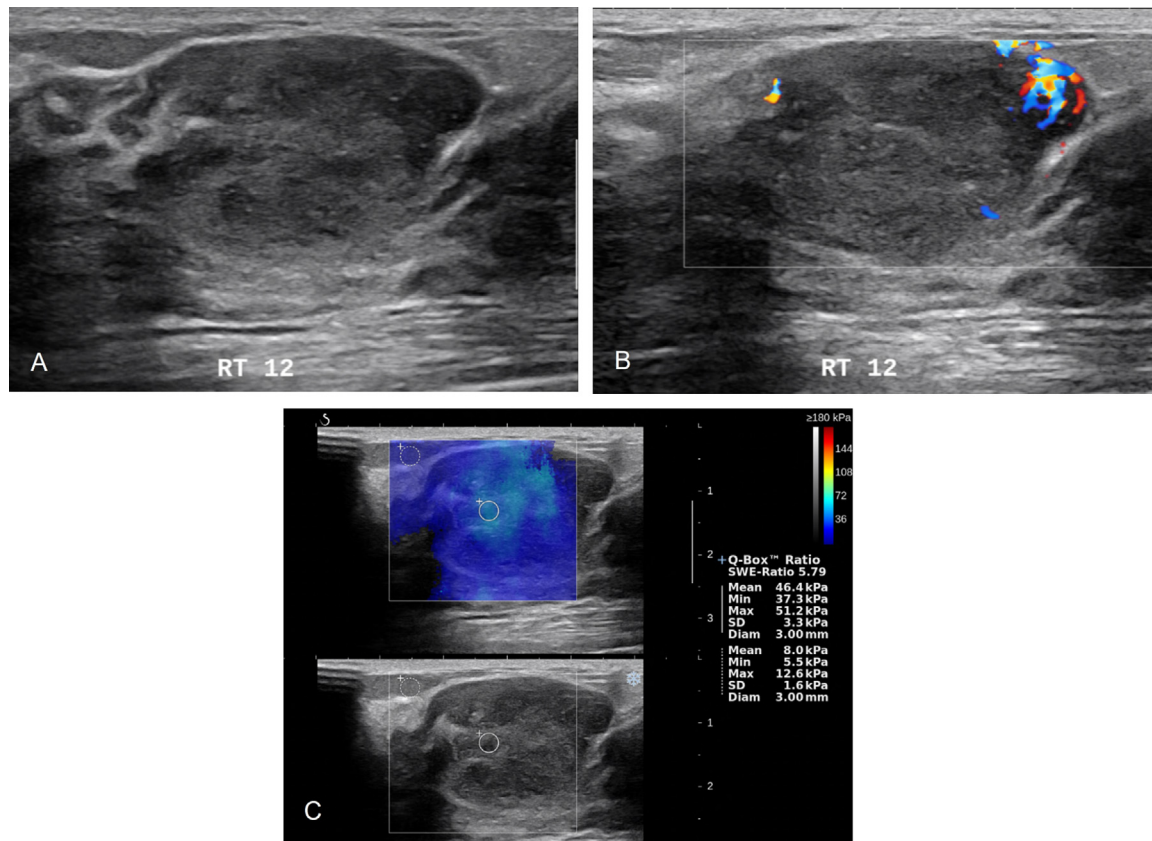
US of a 35-year-old woman with breast lymphoma. (A) Conventional US shows an oval heterogeneous hypoechoic mass with circumscribed, partially indistinct margins and posterior acoustic enhancement in upper center area of right breast. (B) Color Doppler imaging shows vessels in the peripheral portion of mass. (C) SWE image shows E_{\max} of 51.2 kPa, E_{mean} of 46.4 kPa, and mean elasticity ratio of 5.79.
